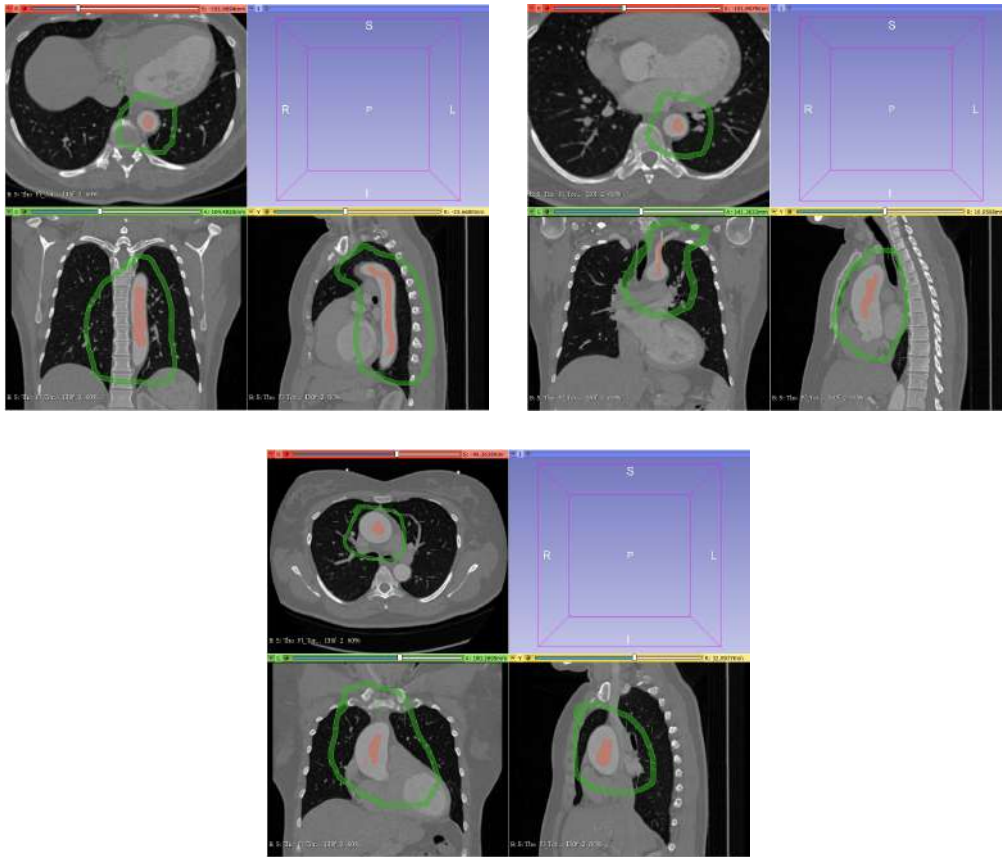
Seeds are planted on the pretended organ and background on different layers of the CT images.
